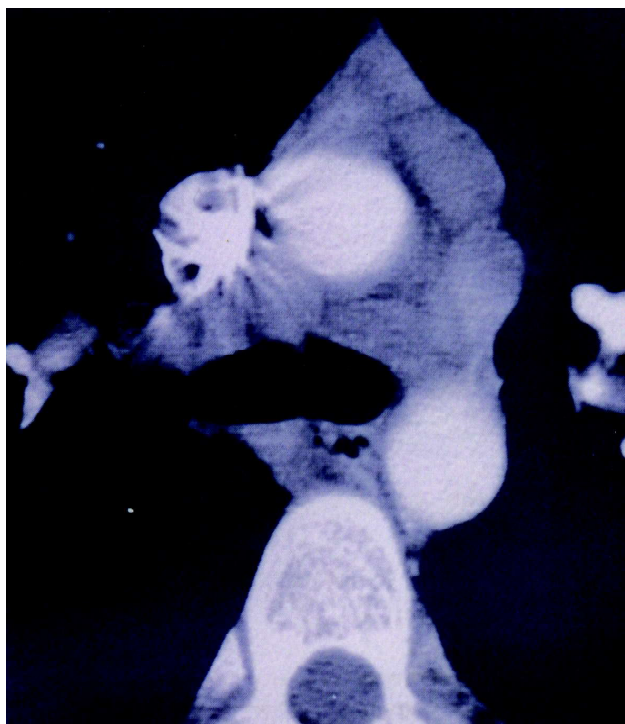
Contrast-enhanced CT scan (CECT) thorax suggestive of right paratracheal and anterior and posterior mediastinal lymphadenopathy.
